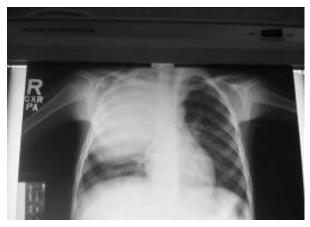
Plain X-ray chest shows huge hydatid cyst in the right lung
